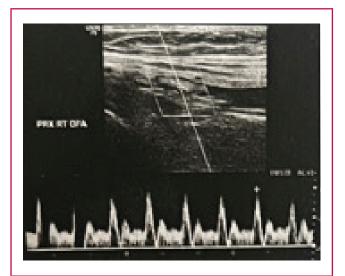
Right lower limb arterial Doppler showing extensive partially occlusive right superficial femoral arterial thrombus causing limb ischaemia and distal posterior tibial artery occlusion. The external iliac, common femoral and deep femoral arteries were spared.
